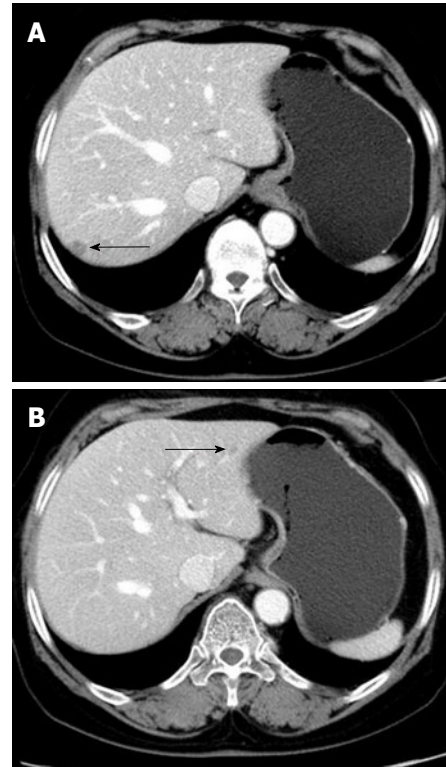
Computed tomography scan showing two hepatic nodules with peripheral enhancement (arrows).
